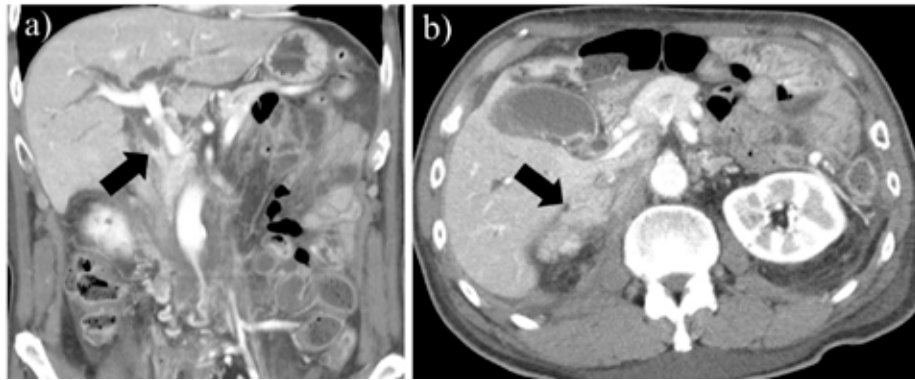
Contrast-enhanced CT tomography a: Stenosis and wall thickening of the common bile duct. b: A soft shadow was observed in the area corresponding to the right adrenal gland.
